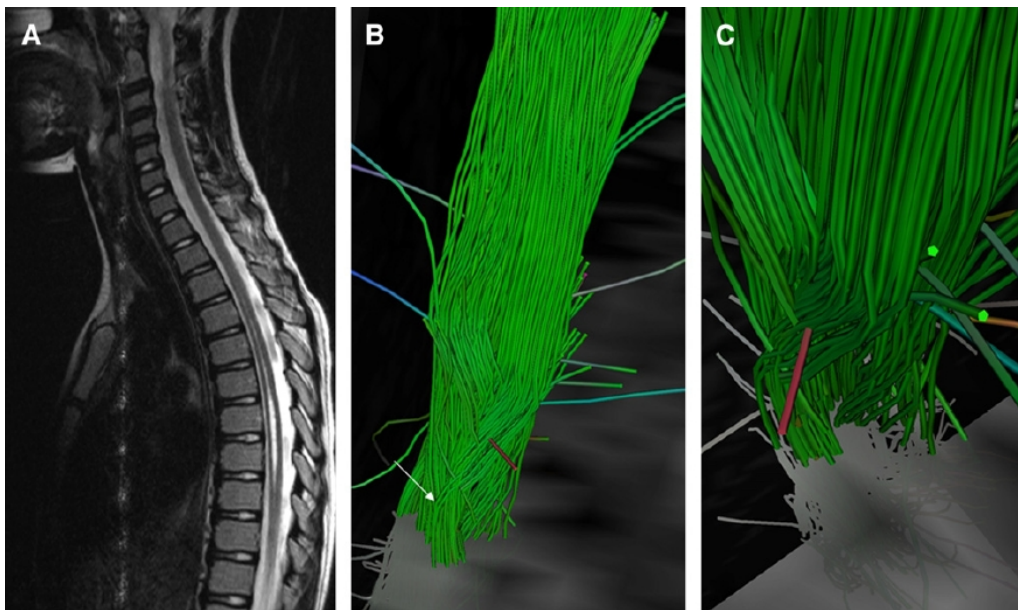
Fluid-filled cavity in the thoracic spinal cord. (A) Midsagittal T2-weighted image shows syrinx in the lower thoracic cord. (B) FT map shows that the syrinx alters the shape of white matter fibers especially the spinothalamic tracts (arrow), which may explain symptoms in some patients. (C) Magnified FT map demonstrates the decussating tracts that are warped by the cavitation (arrow). Objective warping of tracts may lead to decompression even in patients who have small syringes.
